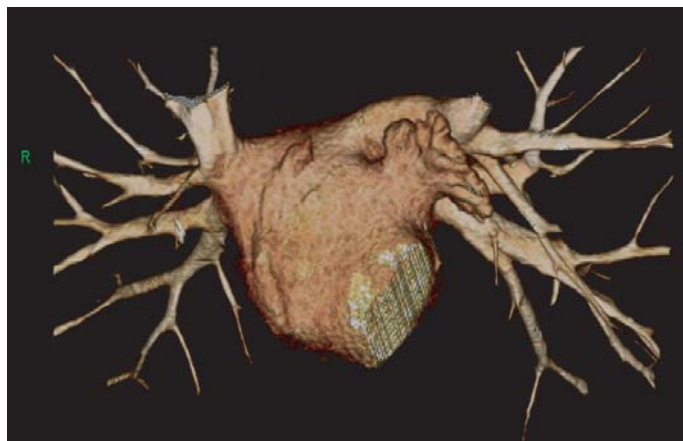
3D image of the left atrium and its associated pulmonary veins and appendage obtained using 16-slice CT and 16×0.75 -mm collimation
